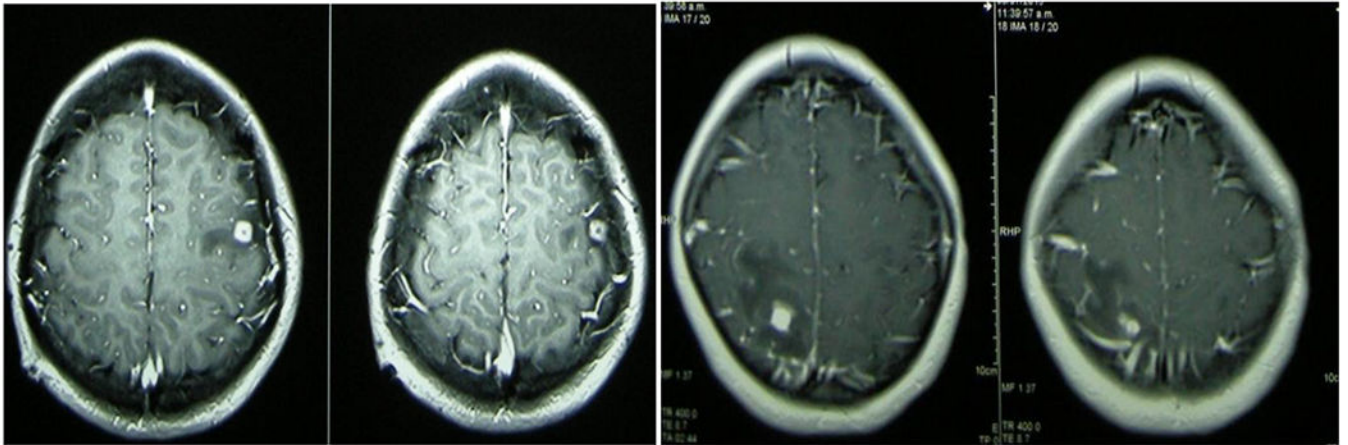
Degenerating cyst (“enhancing lesion”). Contrast-enhanced CT demonstrating a ring enhancing lesion (left) and a nodular enhancing lesion (right), both with perilesional edema. Liquid cyst contents are not noticeable anymore.
